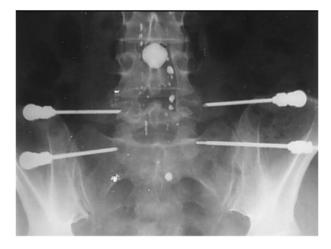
A radiograph of placement of guide cannulae and an electrode for lumbar medial branch radiofrequency neurotomy, published in 1980 [59].
